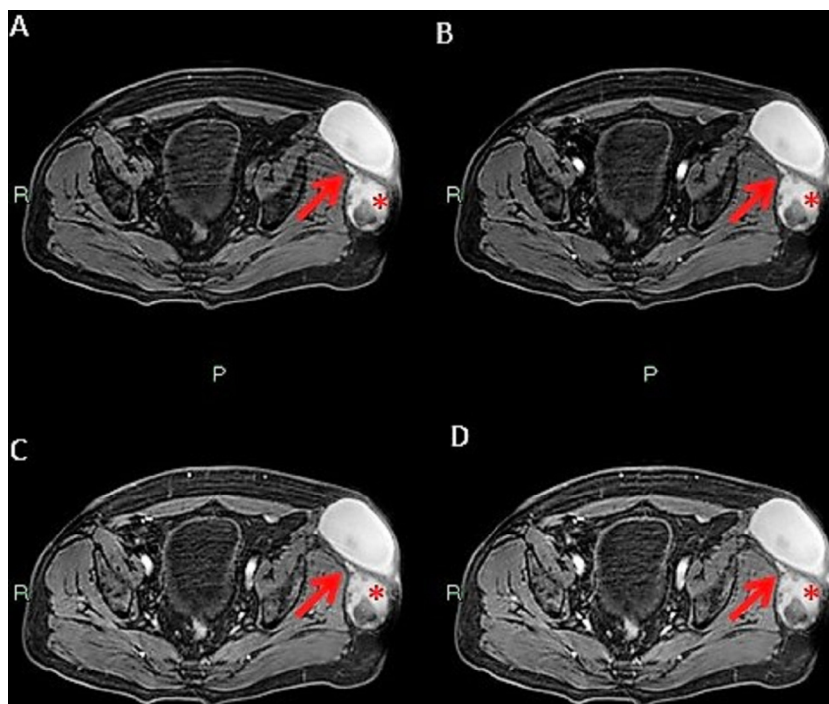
Axial baseline and contrast-enhanced MRI of the pelvis at baseline (A) and in the arterial (B), venous (C), and late (D) phases. Technique: 1.5-T MRI scanner, Sense Torso Coil. 3D GRE T1-weighted sequence at baseline (A) and 25 seconds (B), 55 seconds (C), and 118 seconds (D) after the intravenous administration of the contrast medium (6.5 mL of Gadovist 1.0 mmol/mL; Bayer, Munich, Germany). TR: 4 ms, TE: 2 ms. Baseline scan (A) compared with arterial (B) and venous (C) phase scans. Capsule and inner components (asterisks) of the lesion show poor enhancement with no evidence of infiltration of contiguous tissues (arrows). Fluid-fluid levels are also evident.
